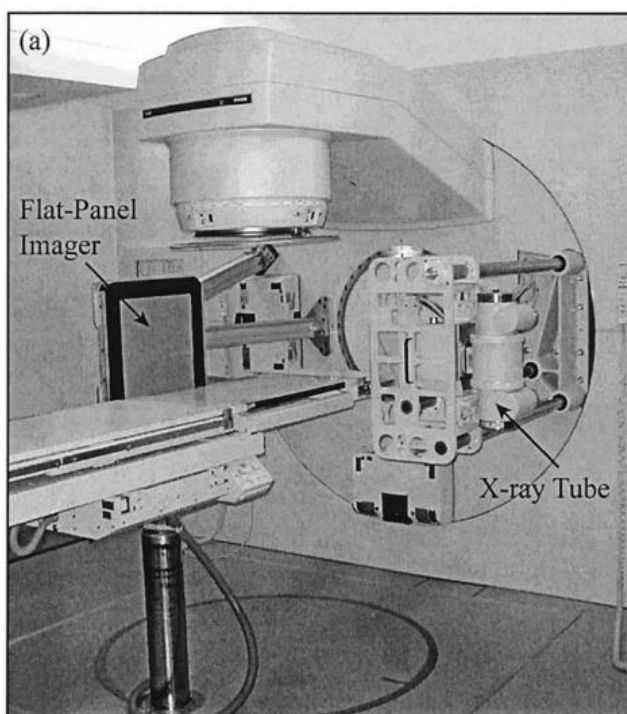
Medical LINAC modified for CBCT. A kV X-ray tube has been mounted on a retractable arm at 90° with respect to the treatment source. Source: Jaffray et al., 2002.
